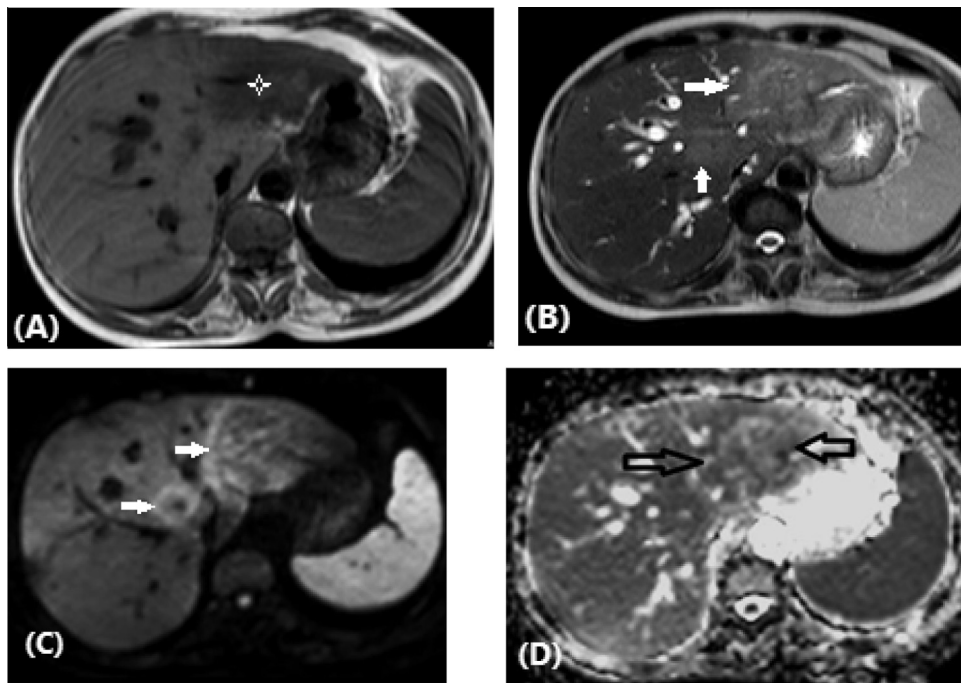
Cholangiocarcinoma in a 55 year-old female patient. (A) Axial T1-weighted image displays an ill-defined hypointense lesion (asterisk) within the left lobe. (B) Axial T2-weighted image, the lesion is slightly hyperintense (arrows). (C) DWI ($b = 600$) image shows peripheral rim of hyperintensity, giving rise to a “target-sign”(arrows). (D) On the ADC map, the lesion is isointense (arrows) with low ADC value ($0.93 \times 10^{-3} \text{mm}^2/\text{s}$).
